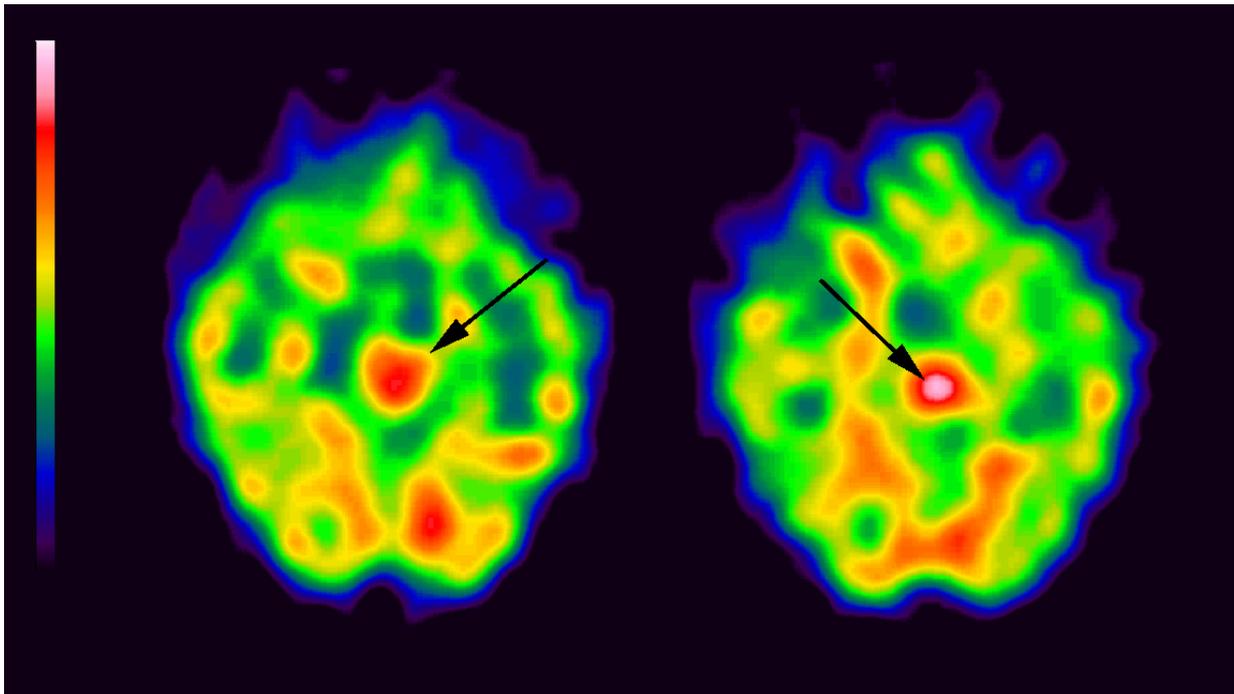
SPECT scan of a recovered patient before (left) and after recovery (right) from depression. The arrows indicate the midbrain region. The increase in [ $^{123}\text{I}$ ] $\beta$ -CIT binding is shown as brighter colour (white).
